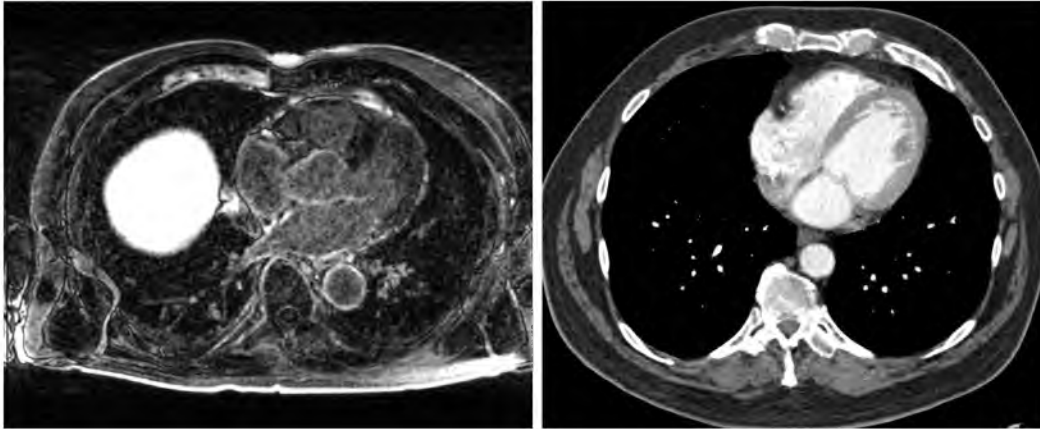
MRI and CT axial slices of a human torso MRI scan.
